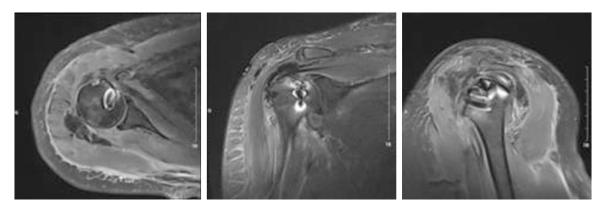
Postoperative MRI of the right shoulder. The supraspinatus and subscapularis tendons are complete and continuous without any retraction. The distance of acromion-humeral head is normal.
